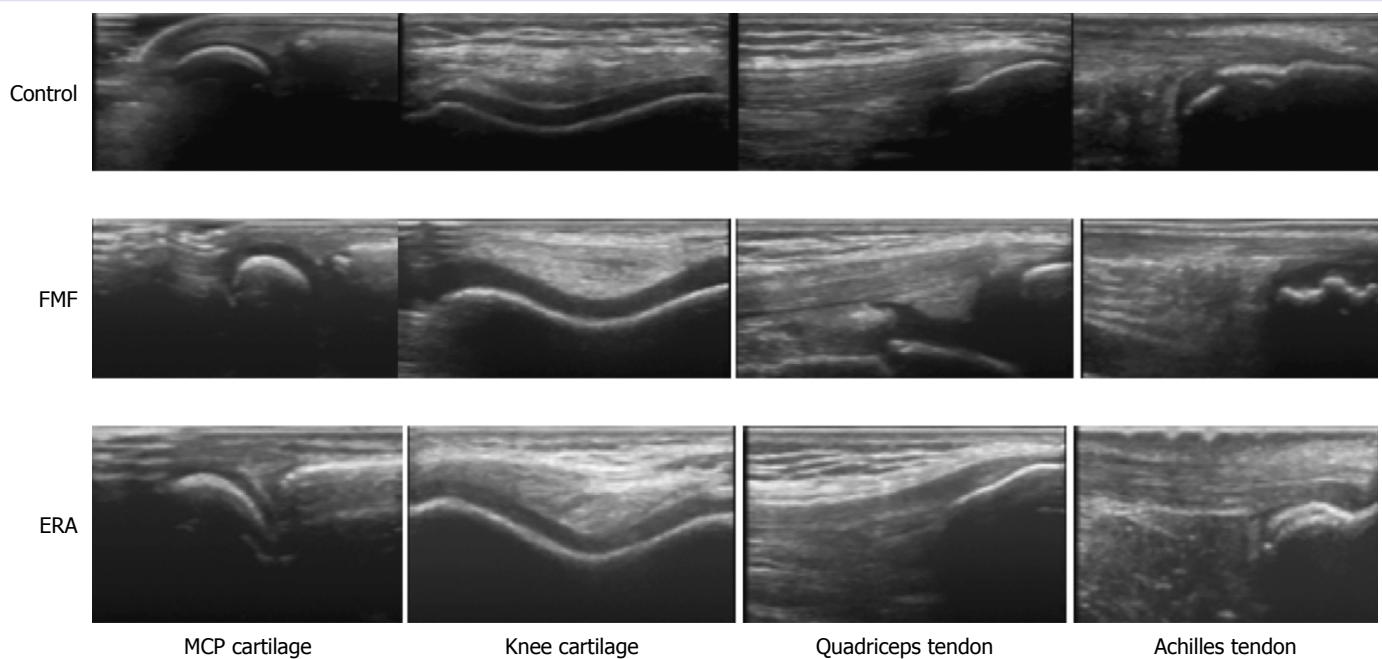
Ultrasonographic appearances of cartilage and entheses.
